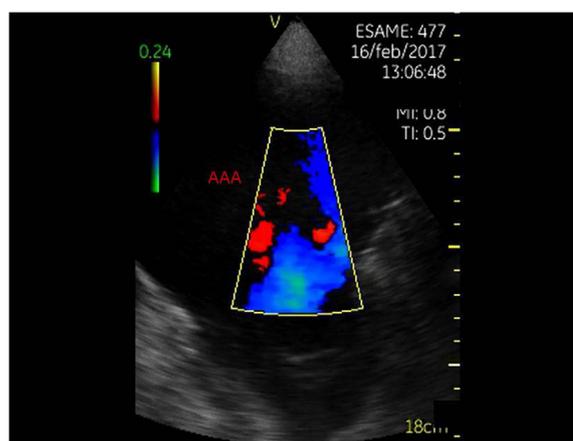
Point-of-care abdominal ultrasound with color Doppler: a giant abdominal aortic aneurysm. AAA: abdominal aortic aneurysm.
